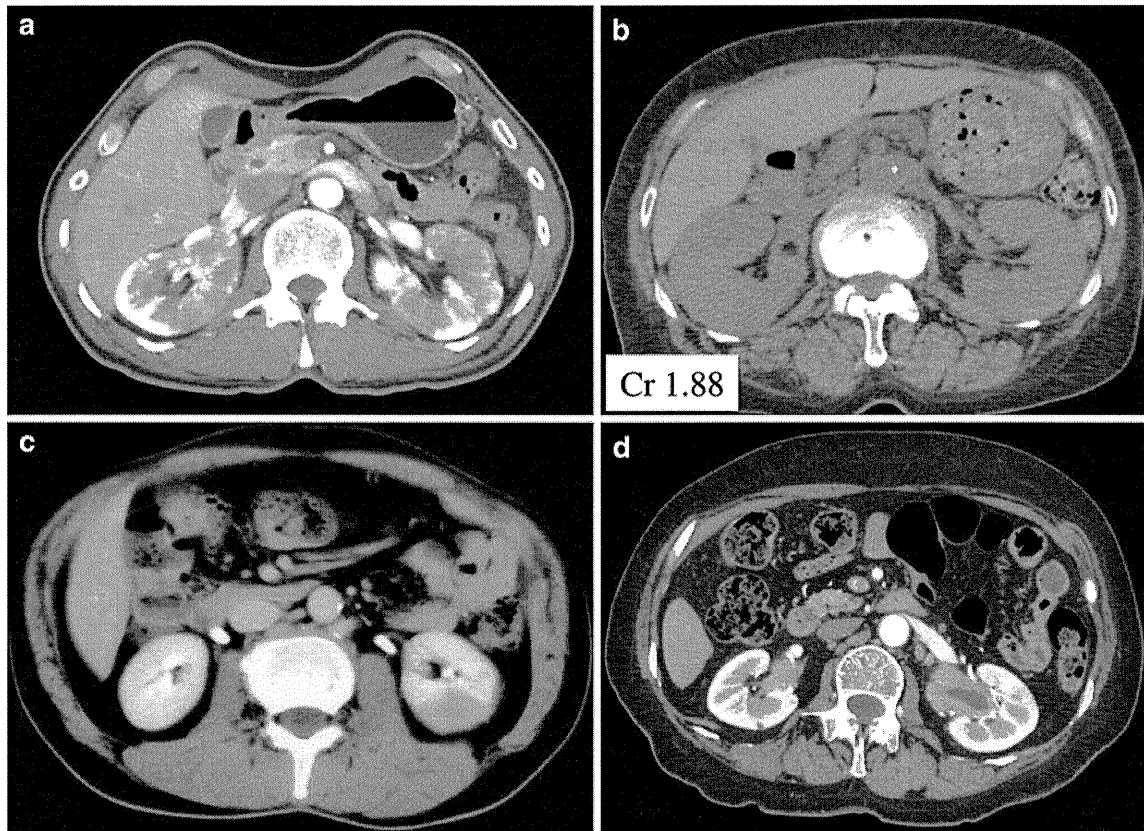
Characteristic renal computed tomography (CT) imaging. a Multiple low-density lesions on enhanced CT. b Diffuse bilateral renal swelling. c A hypovascular solitary nodule. d Diffuse thickening of the renal pelvis wall with smooth intra-luminal surface
